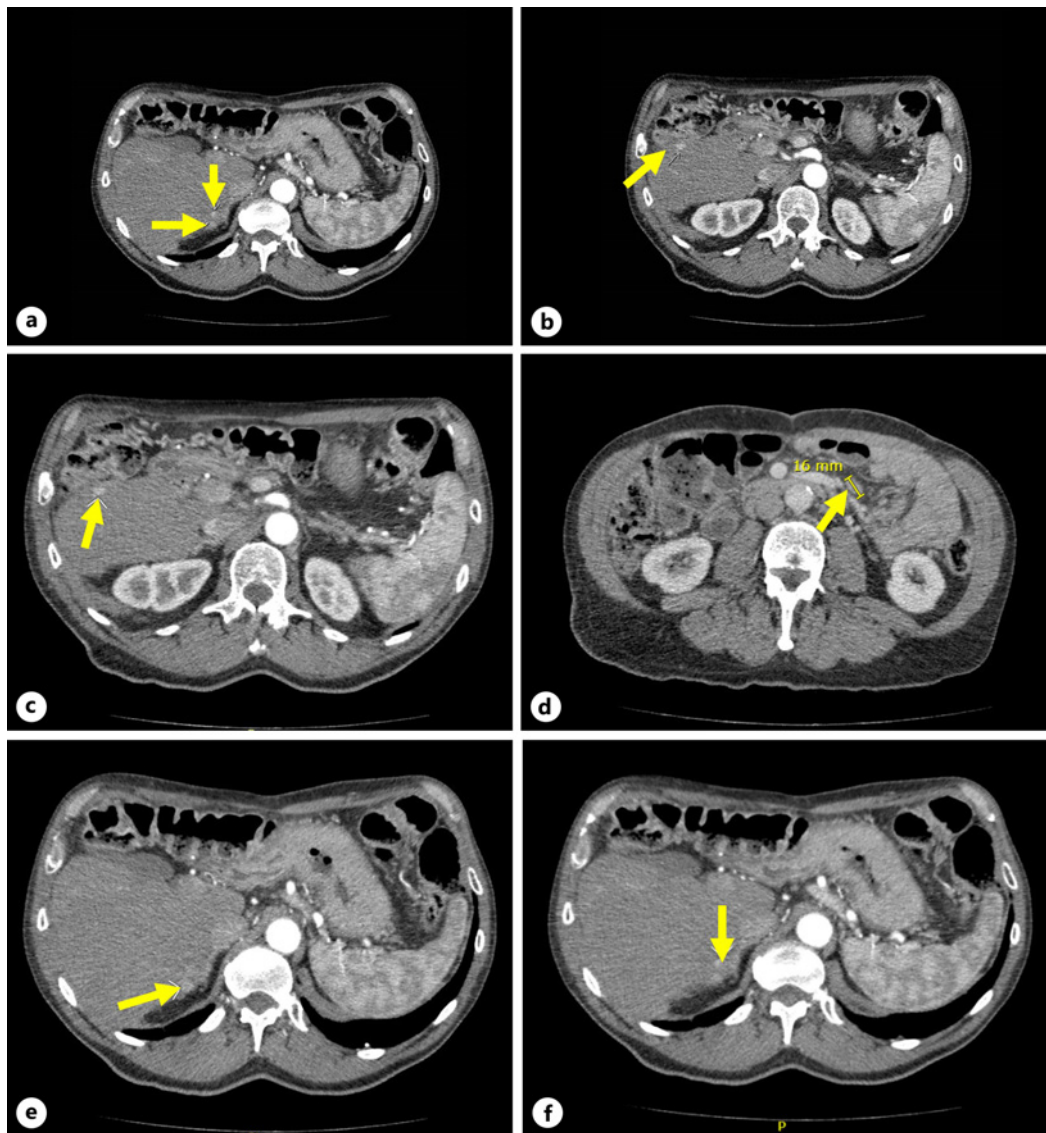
a, b CT scans of the patient's abdomen at initial diagnosis (November 2011) with arrows indicating 4-cm and 3-cm masses in the hepatic segment VIII. c–f CT scans of the patient following disease progression after nivolumab treatment for 51 months (September 2019). c Arrow indicates the 10-mm lesion in the hepatic segment V. d Arrow indicates the 16-mm lesion in the mesenteric node. e, f Arrows indicate the 10-mm and 7-mm lesions in hepatic segment VI. Models courtesy of Novocure Ltd, Haifa, Israel.
